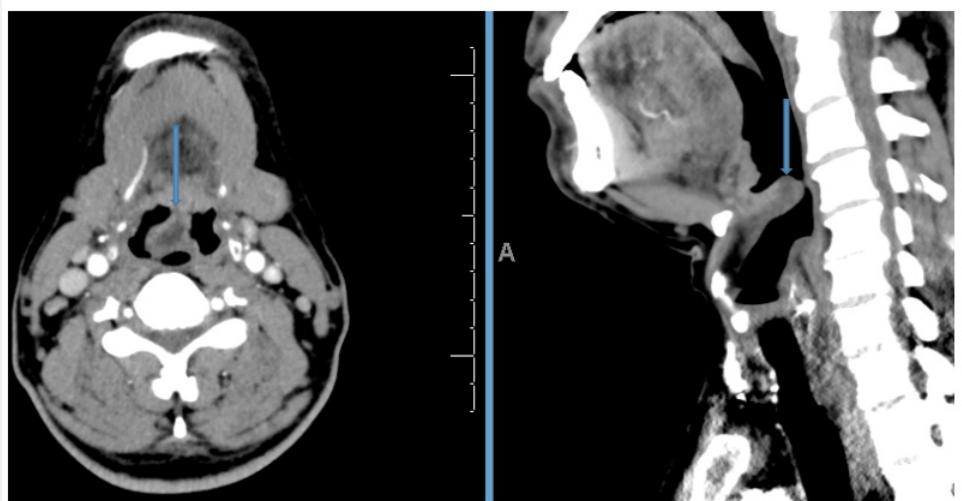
CT scan neck with contrast revealed - Epiglottic abscess reaching up to vallecula (arrow).
